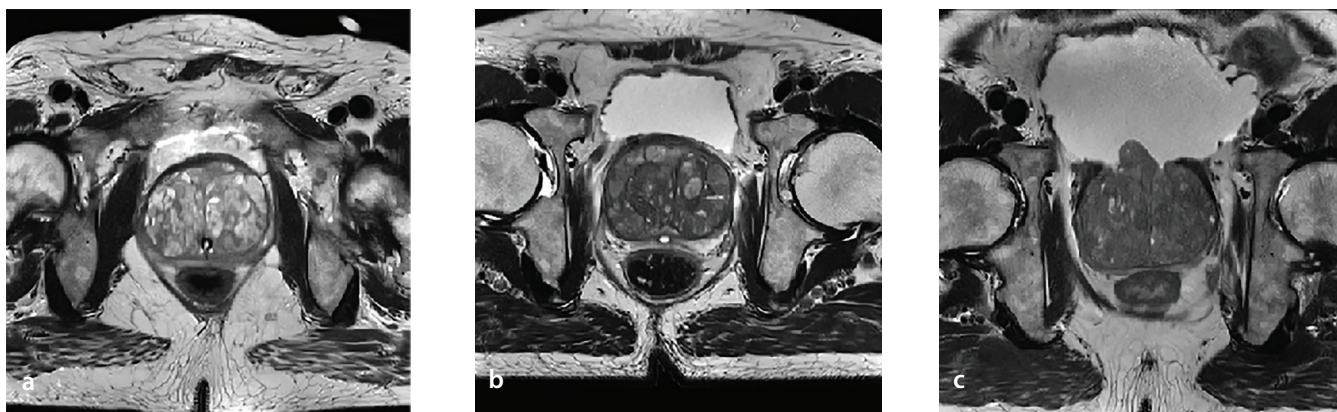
Representative T2-weighted magnetic resonance imaging patterns of transition zone phenotypes in benign prostatic hyperplasia. (a) Glandular-dominant phenotype: the transition zone is predominantly composed of glandular nodules, which present as high-signal structures on T2-weighted imaging (T2WI), exhibiting acinous or microcystic morphology. These nodules are easily distinguishable from the surrounding stromal tissue due to their high signal intensity. (b) Mixed phenotype: the transition zone shows a combination of glandular and stromal nodules. The glandular nodules are present but not dominant in size, exhibiting alternating high and low signal intensities on T2WI. This phenotype reflects the heterogeneous composition of the transition zone, with both glandular and stromal components clearly visible. (c) Stromal-dominant phenotype: the transition zone is primarily composed of stromal nodules, with fewer glandular nodules. The stromal tissue appears as low-signal structures on T2WI, exhibiting a lamellar or fibromuscular texture, typical of benign stromal hyperplasia.
